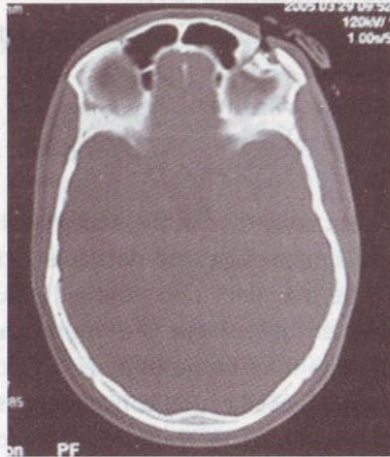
CT scan showing fracture of left orbital roof
